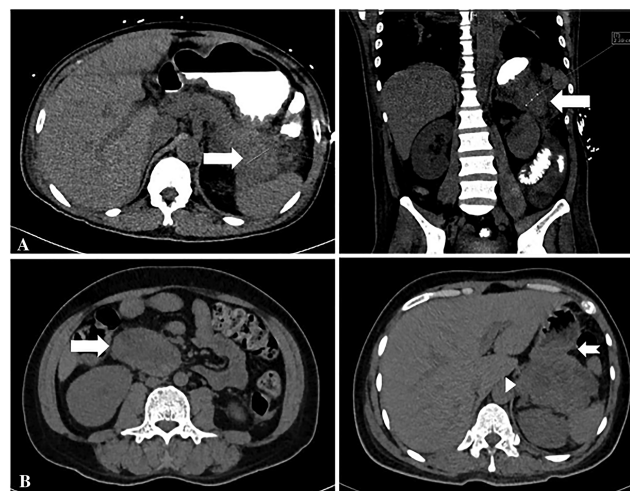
A. Acute necrotizing pancreatitis: computed tomography (CT) scan.* The pancreas is diffusely enlarged with peripancreatic nodularities and fat stranding. There is disruption of the pancreatic duct at the pancreatic tail (arrow) with concomitant contusion of pancreatic parenchyma. B. Pancreatic and peripancreatic fluid collections: computed tomography (CT) scan.* CT scan showing a thick-walled, mixed-attenuating, heterogeneous mass measuring 5.0 x 7.2 x 4.0 cm at region of the pancreatic head consistent with a walled-off necrosis (arrow). An irregular, mixed attenuating focus in the pancreatic tail consistent with an acute necrotizing collection (arrow head) is seen closely associated with the stomach (notched arrow).
